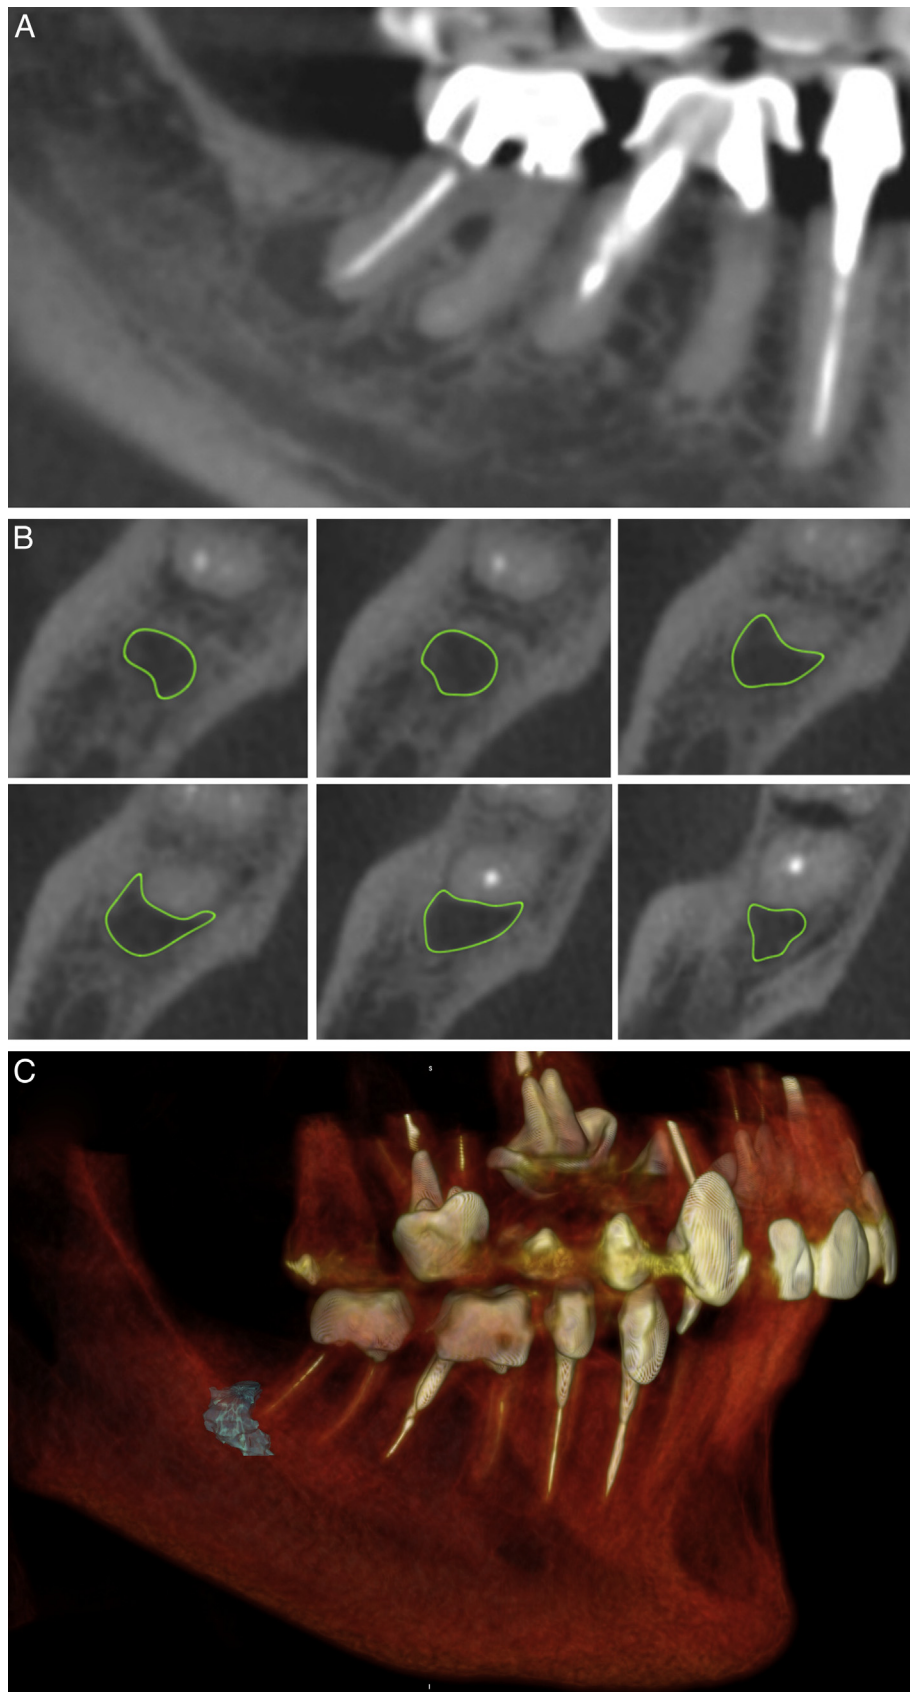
Manual segmentation method. (A) A coronal panoramic view of a PL in the distal root of the right lower molar. (B) A PL outlined in the axial CBCT cuts. (C) Volume calculation output.
